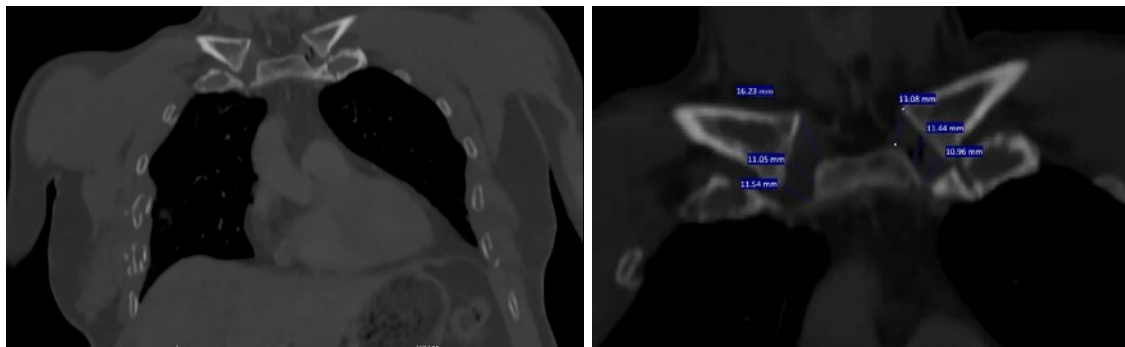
a) Coronal reformatted CT image in the bone window. The right SCJ is enlarged compared with the left side with multiple rib fractures seen on the right. Gas is present within the left SCJ. b) Coronal reformatted CT image in the bone window shows relative expansion of the right superior part of SCJ compared with the left side.
